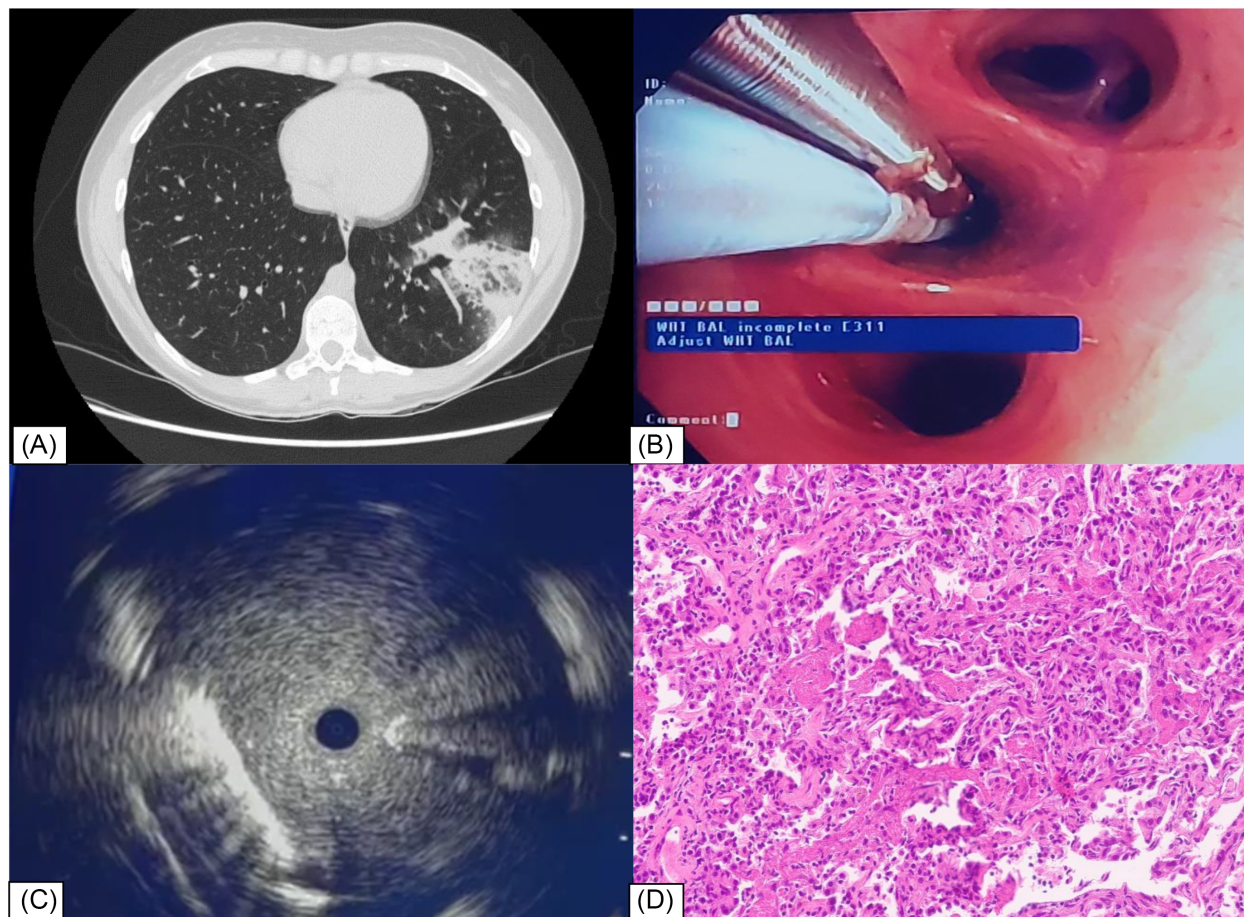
(A) CT scan with LLL consolidation. (B) Radial probe and fogarty balloon attached: Endoscopic view. (C) Radial mini probe ultrasonographic image with distinct ‘shadowing’ of the 1.1 cryoprobe. (D) Bronchiolar walls infiltrated by inflammatory cells, primarily lymphocytes, with scattered neutrophils.
